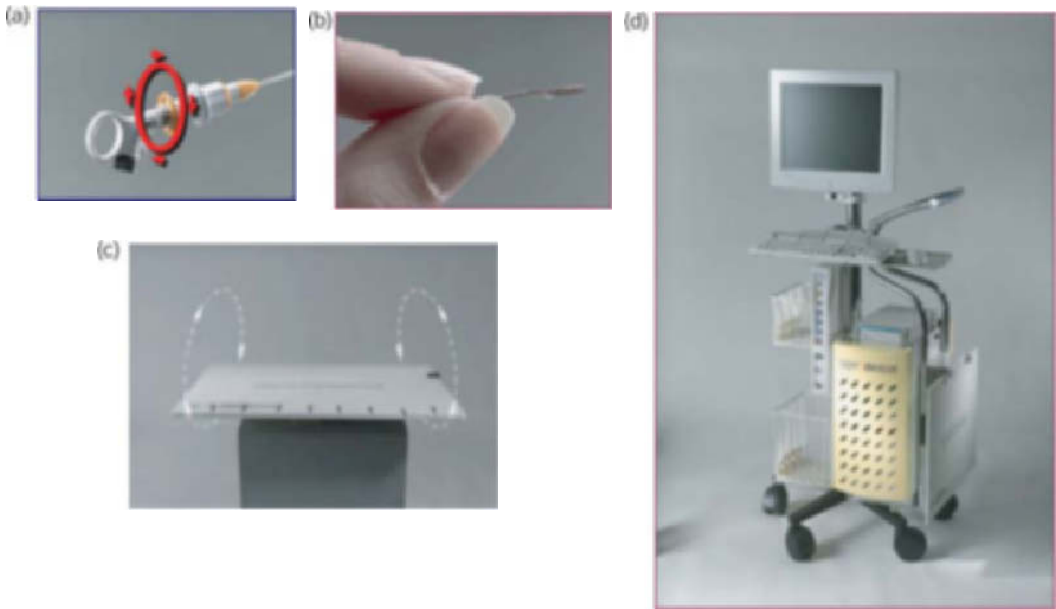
The SuperDimension bronchial system (SDBS™, SuperDimension Co., Herzliya, Israel) consists of a steerable guide (a), bearing an electronic sensor at its tip (b) that can be localized within a magnetic field around the patient's upper body, created by a magnetic board (c) that is placed on the examination table. The sensor is connected to a computer and can be followed on a three planar CT on the computer screen that is superimposed on the patient's real anatomy (d).
